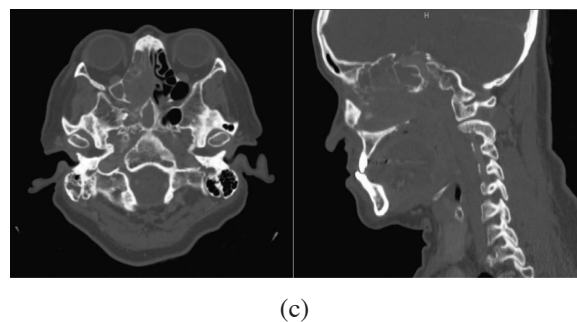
(c) Staging CT scan performed a month later showed a large soft tissue mass with bony destruction at adjacent medial wall of right maxillary sinus, right ethmoid sinus, inferior wall of sphenoid sinus, medial aspect of right pterygoid plate and right nasal septum.
